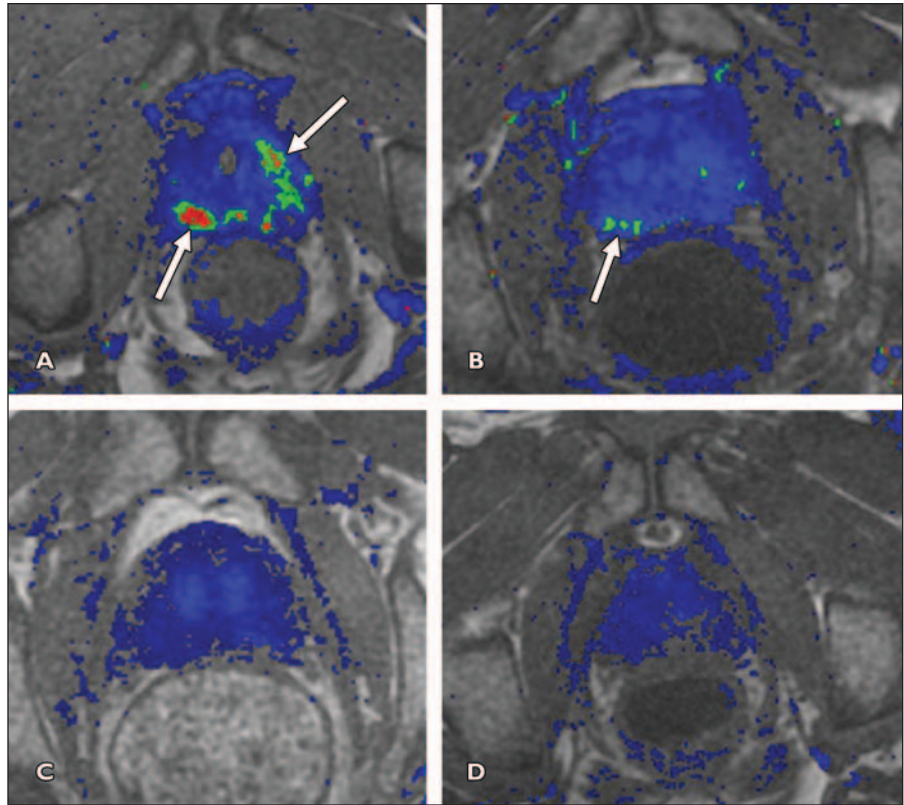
64-year-old man with Gleason 6 bilateral prostate cancer confirmed with biopsy. A–D, Pretreatment dynamic contrast-enhanced MRI (DCE-MRI) colorized permeability map (A) depicts bilateral peripheral zone tumors (arrows) (median K^{trans} , 1.79 minutes⁻¹; prostate-specific antigen [PSA] concentration, 8.2 ng/mL). Follow-up DCE-MR image 2 months after radiation therapy (B) shows interval improvement with decreasing tumor (arrow) (median K^{trans} , 0.87 minutes⁻¹; PSA concentration, 3.7 ng/mL). DCE-MR image 6 months after radiation therapy (C) shows resolution of all enhancing tumors (median K^{trans} , 0.19 minutes⁻¹; PSA concentration, 1.8 ng/mL). DCE-MR image 12 months after radiation therapy (D) shows decreased enhancement of prostate with no evidence of residual or recurrent tumor (median K^{trans} , 0.13 minutes⁻¹; PSA concentration, 0.6 ng/mL). E, Graph of standardized serial PSA concentration (◆) and DCE-MRI tumor permeability surface area product (K^{trans}) (■) before and after radiation therapy shows percentage decrease compared with pretreatment values. Progressive decline in serum PSA concentration and K^{trans} indicates response of prostate cancer to radiation therapy.
